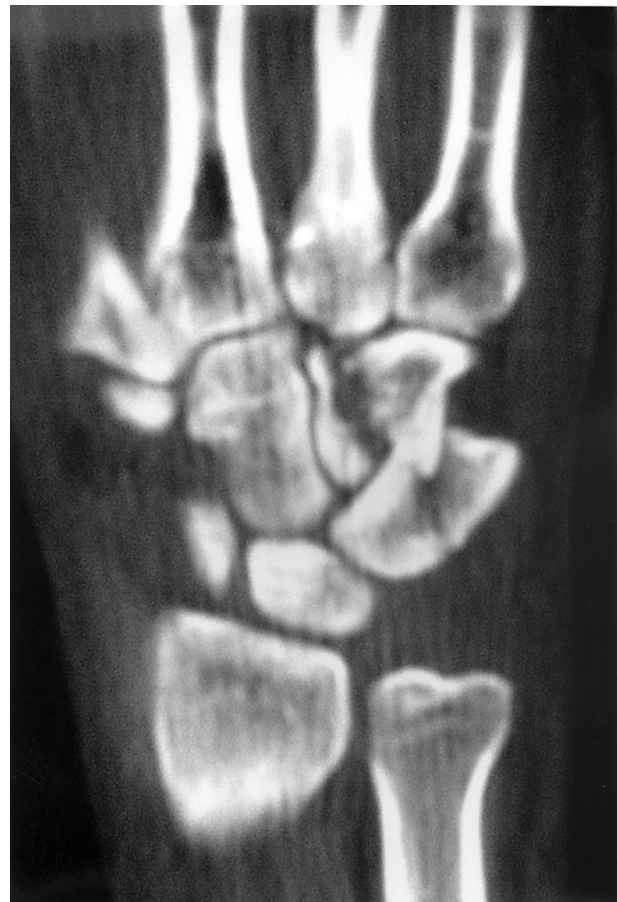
2D coronary CT section of the patient's injured right wrist. The fragment of the hamate intervenes with the fragments of the triquetrum.
